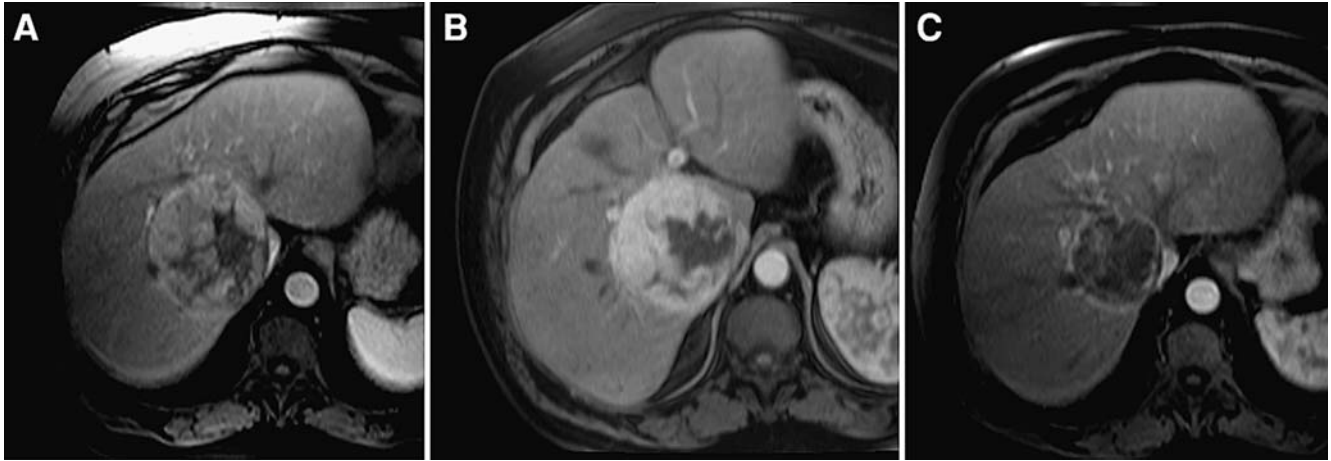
(A) Pre-treatment gadolinium-enhanced T1-weighted MRI demonstrates a heterogeneously enhancing caudate lobe (segment I) hepatoma. Serum AFP value was 2,200 ng/dL. (B) At 1 month follow-up imaging, gadolinium-enhanced T1-weighted imaging demonstrates the enhancing caudate hepatoma with no change in tumor size. Tumor is categorized as stable disease by size criteria. Serum AFP values dropped to 125 ng/dl, representing a 94.3% reduction. Rather than
